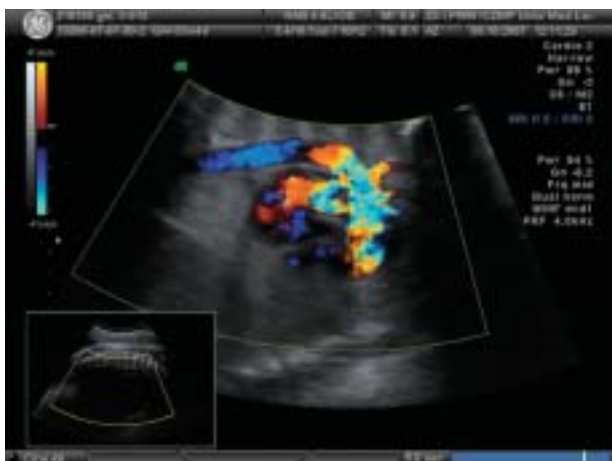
Foetal echocardiography (the same patient). Long-axis view of MAPCAs in color Doppler presentation
